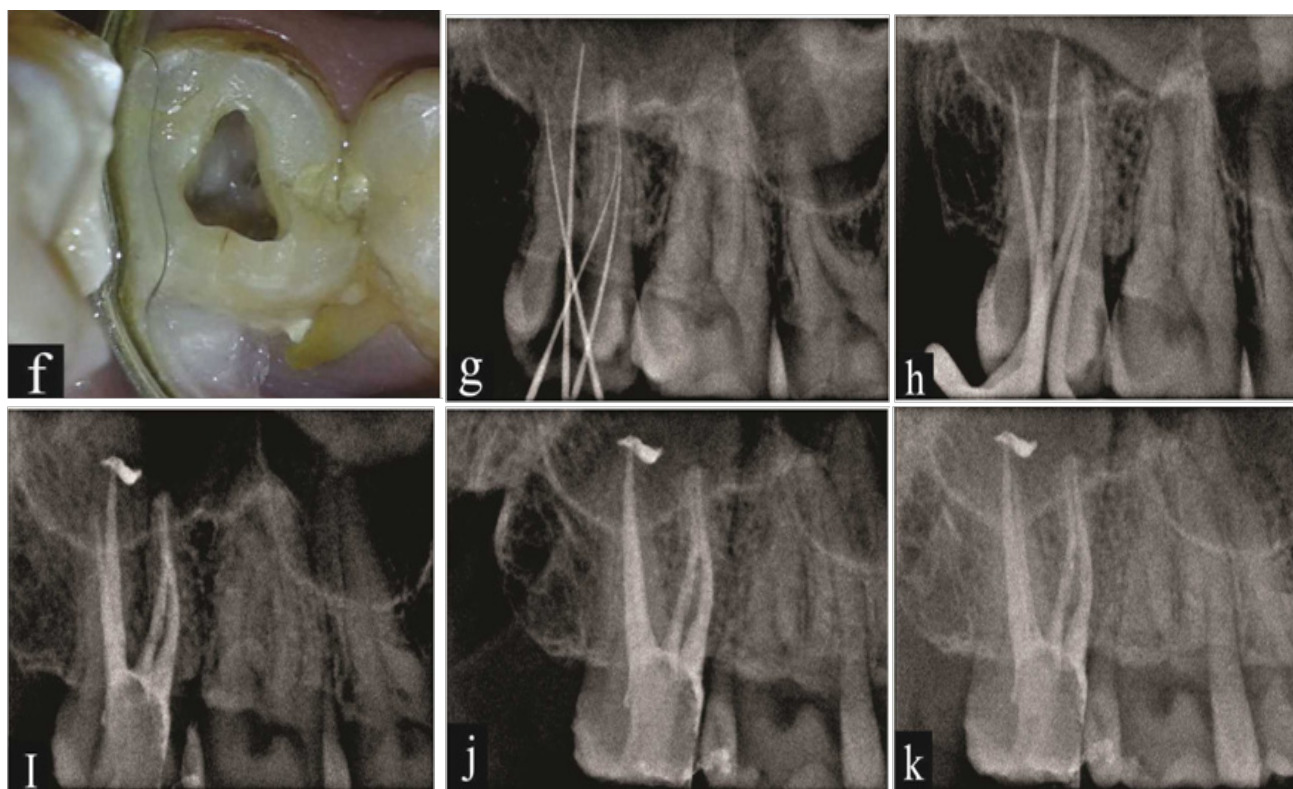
f) Access cavity preparation under DOM 8x; g) Working length radiograph; h) Radiograph with master guttapercha in place; i) Immediate post obturation radiograph; j) Follow up radiograph after three months; k) Follow up radiograph after six months.
